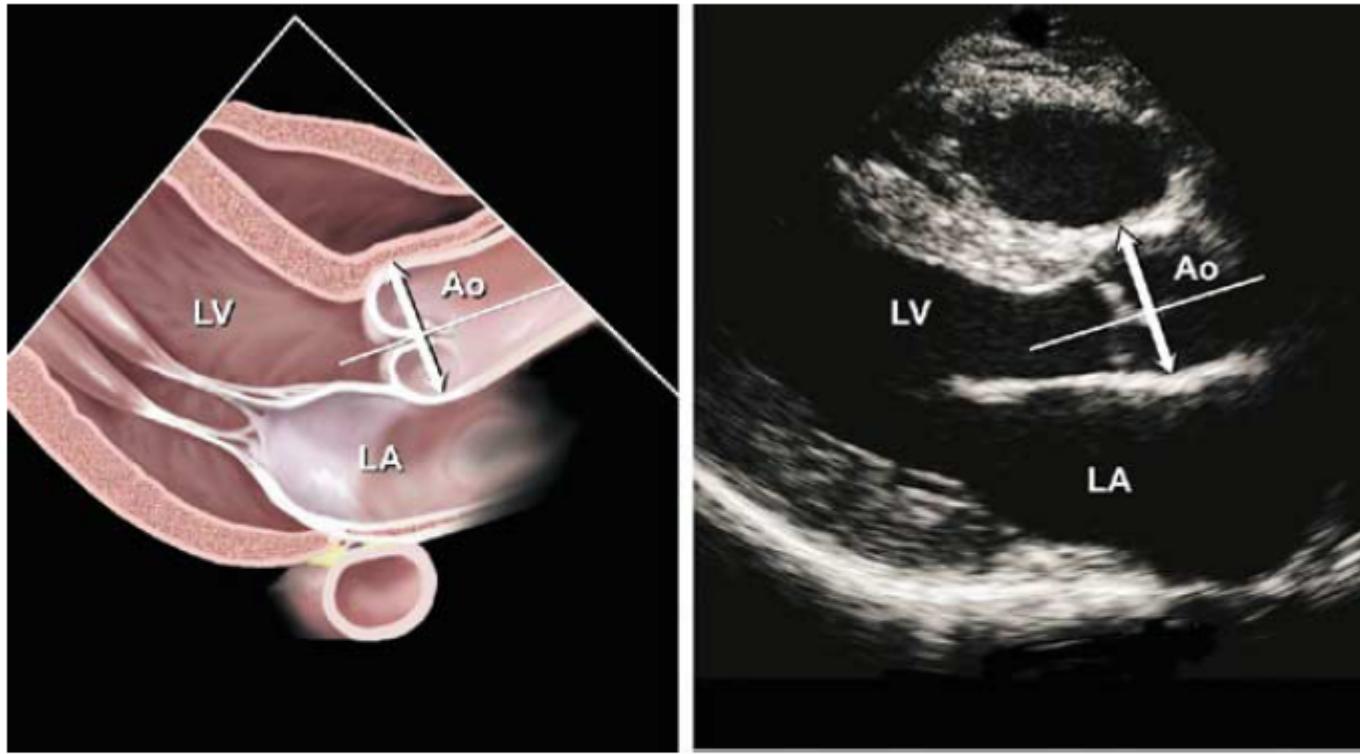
Measurement of aortic root diameter at sinuses of Valsava from 2-dimensional parasternal long-axis image. Although leading edge to leading edge technique is shown, some prefer inner edge to inner edge method. (See text for further discussion.)
